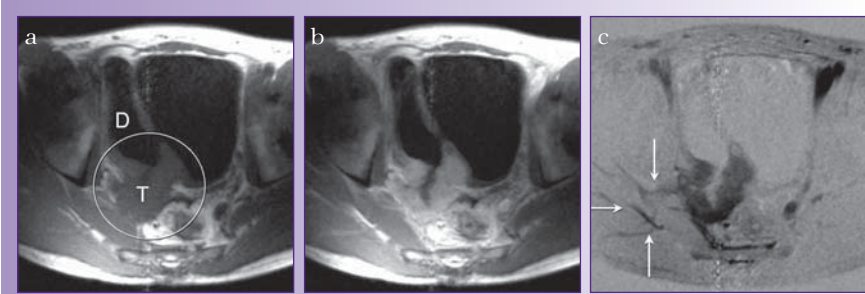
Patient with bladder diverticulum (D) and invasive cancer (stage T4B). (a) Axial T1-weighted GRE image shows tumour extending into the perivesical fat (circle). (b) Same image two minutes post-contrast injection shows more enhancement of tumour compared to wall. (c) Subtraction of a and b shows tumour enhancement in between the pelvic muscles (arrows). This infiltration is not visible on the T2-weighted images (see Figure 4). Reprinted with permission from Springer Verlag.¹⁰
